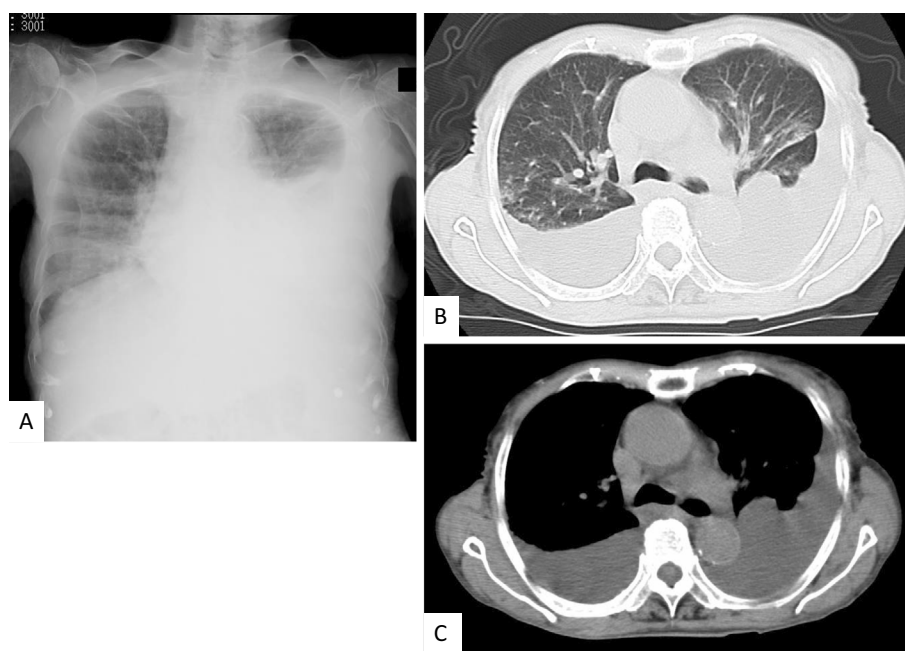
Chest radiography (A) and computed tomography (B, C) taken upon admission showing bilateral pleural effusion without apparent pulmonary lesions or thickened pleura.
